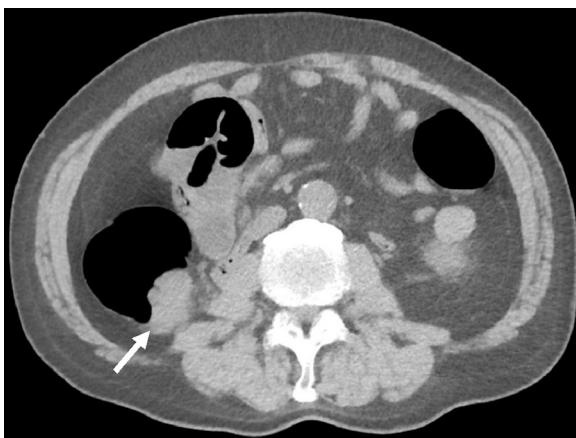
Computed tomography shows wall thickening in the ascending colon.
